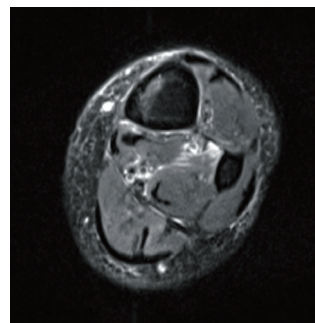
Axial T2 turbo spin echo magnetic resonance imaging of the left lower extremity (Feb 3<sup>rd</sup>). There is no sign of fracture. It showed high signal changes within the anterior and posterior deep compartment of the muscle (muscle strain).
